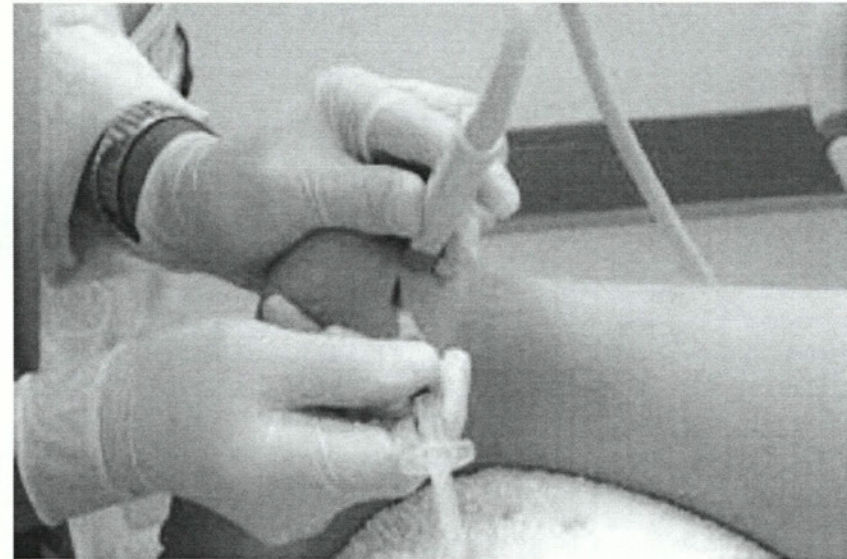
Ultrasound guided Achilles PRP injection⁹.
